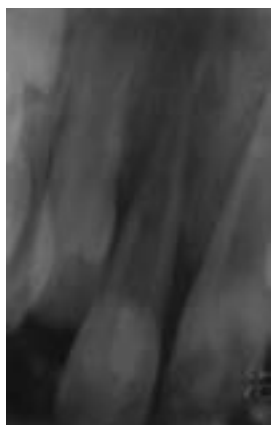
Radiographic image at 3 months recall
